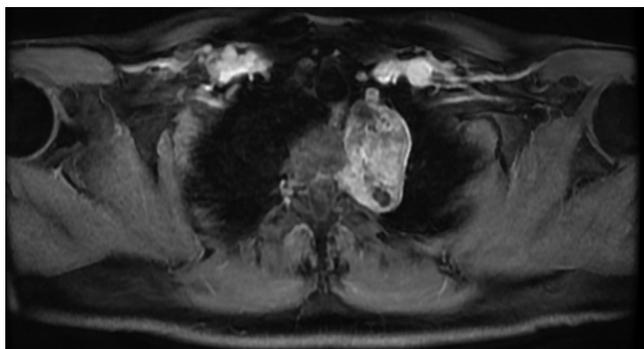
Magnetic resonance image of a schwannoma located in the posterior mediastinum
